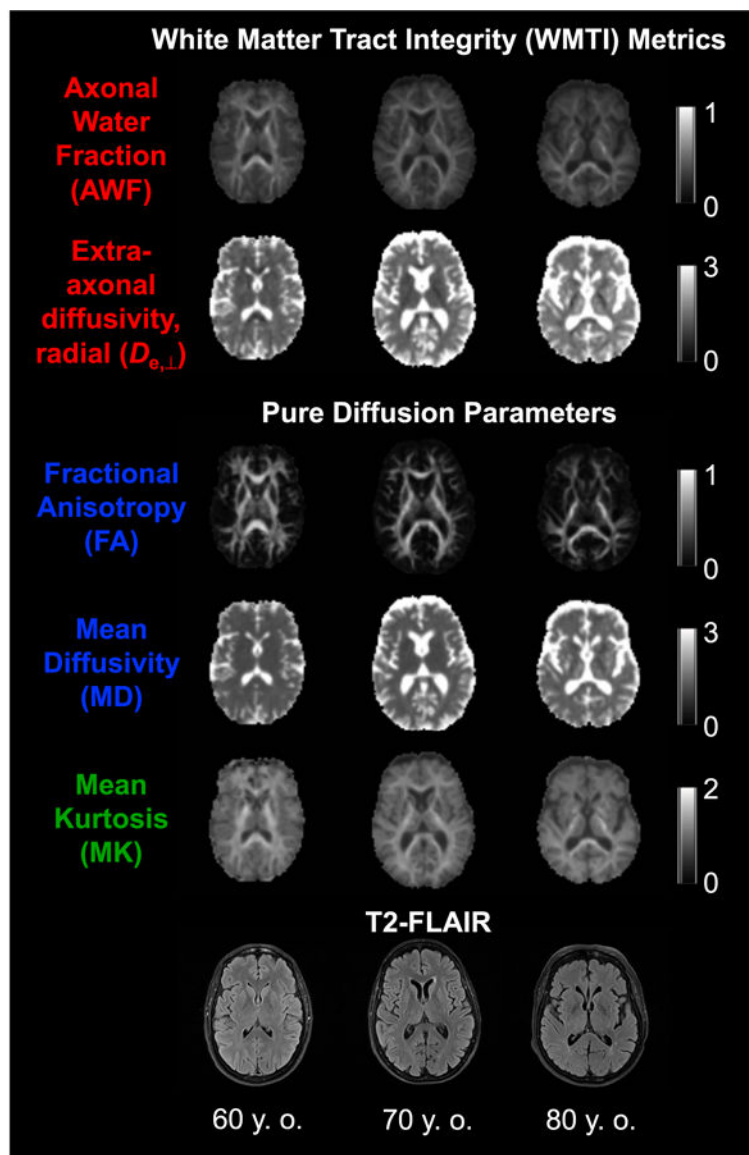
Metrics obtained using DKI. DKI parametric maps and T2-FLAIR images of 60-, 70-, and 80-year-old participants (all female, white, and right-handed). The calibration bars for the diffusivities are in units of mm^2/ms , whereas those for the AWF, FA, and MK are dimensionless. Abbreviations: AWF, axonal water fraction; DKI, diffusional kurtosis imaging; FA, fractional anisotropy; MK, mean kurtosis.
